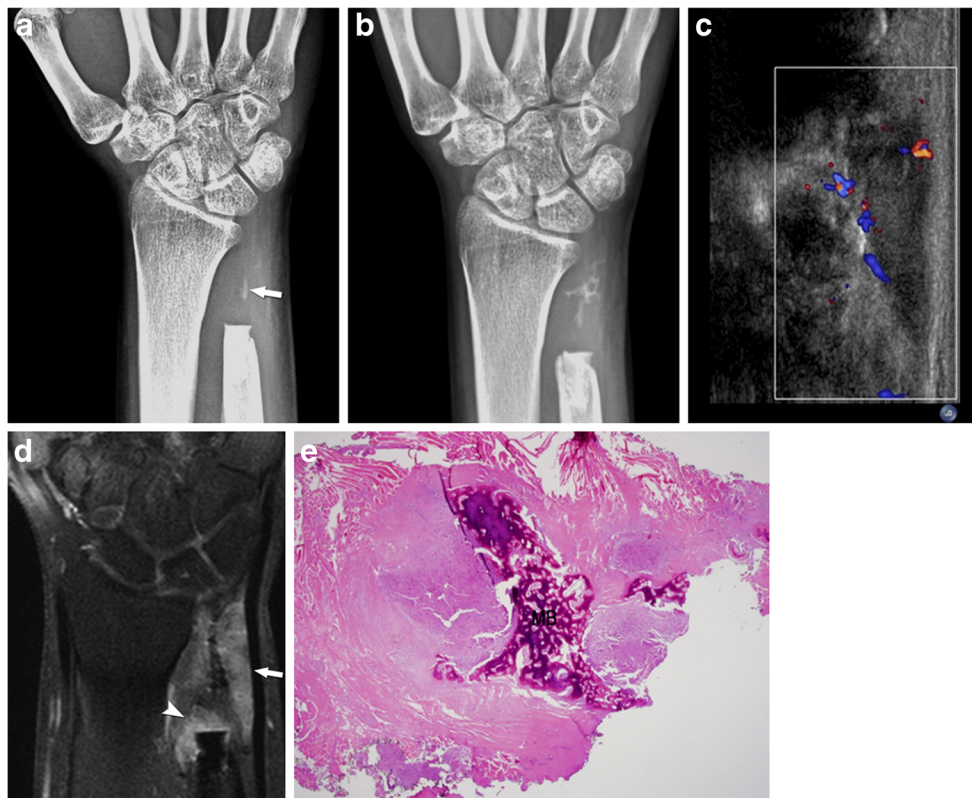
Case 4. A 35-year-old female with giant cell tumor in right distal ulna. a, b On serial follow-up radiographs of anterior-posterior projection of the wrist taken 10 months (a) and 21 months (b) after the second operation, a focal radiodense lesion (*arrow*) in the soft tissue, near the distal margin of the resected ulna, is gradually increasing in density and size, forming an irregular stellate appearance. c Ultrasonography obtained at the 19-month follow-up shows a triangular low echoic soft tissue lesion distal to the bone resection site. Focal color signals are present in the peripheral portion on color Doppler imaging. d 21-month follow-up MR
